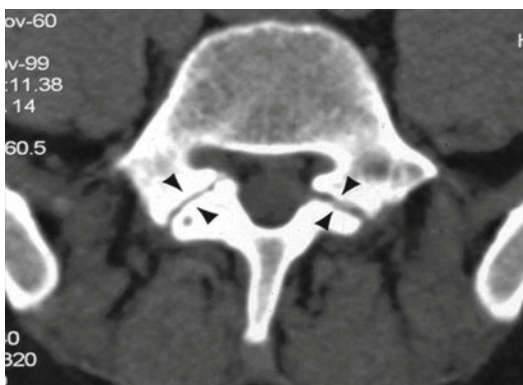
Axial view of a CT scan of the lumbar spine demonstrating bilateral pars defects (*arrowheads*)
